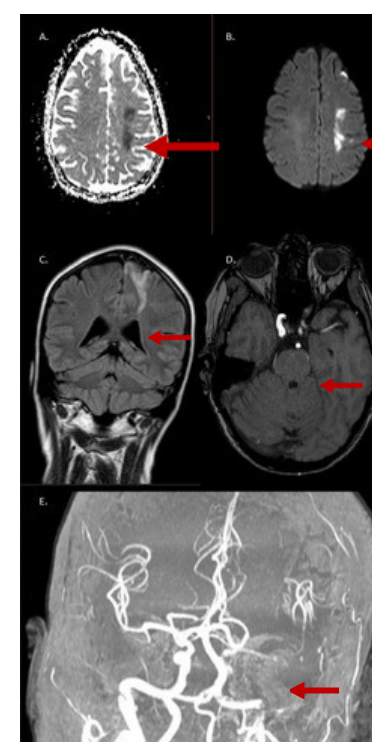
MRI scan of brain confirming stroke. Red arrows for area of interest. A & B: Diffusion weighted and ADC images showing acute stroke. C. FLAIR-LONGTR sequence showing the extent of infarction. D. T2W-TSE showing partially occluded MCA, possibly due to thrombus/emboli. E. 3Di-MC showing 3d visualisation of the vessels.
